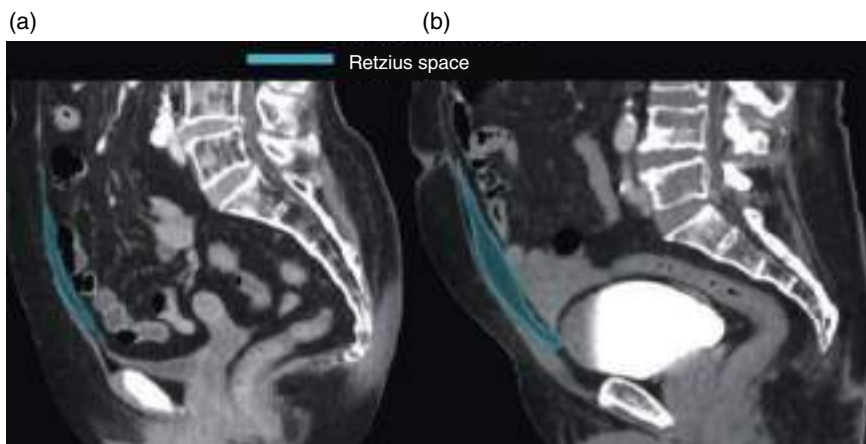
(a) Sagittal contrast-enhanced MPR CT image (portal venous phase). (b) Sagittal contrast-enhanced MPR CT image (late venous phase).
